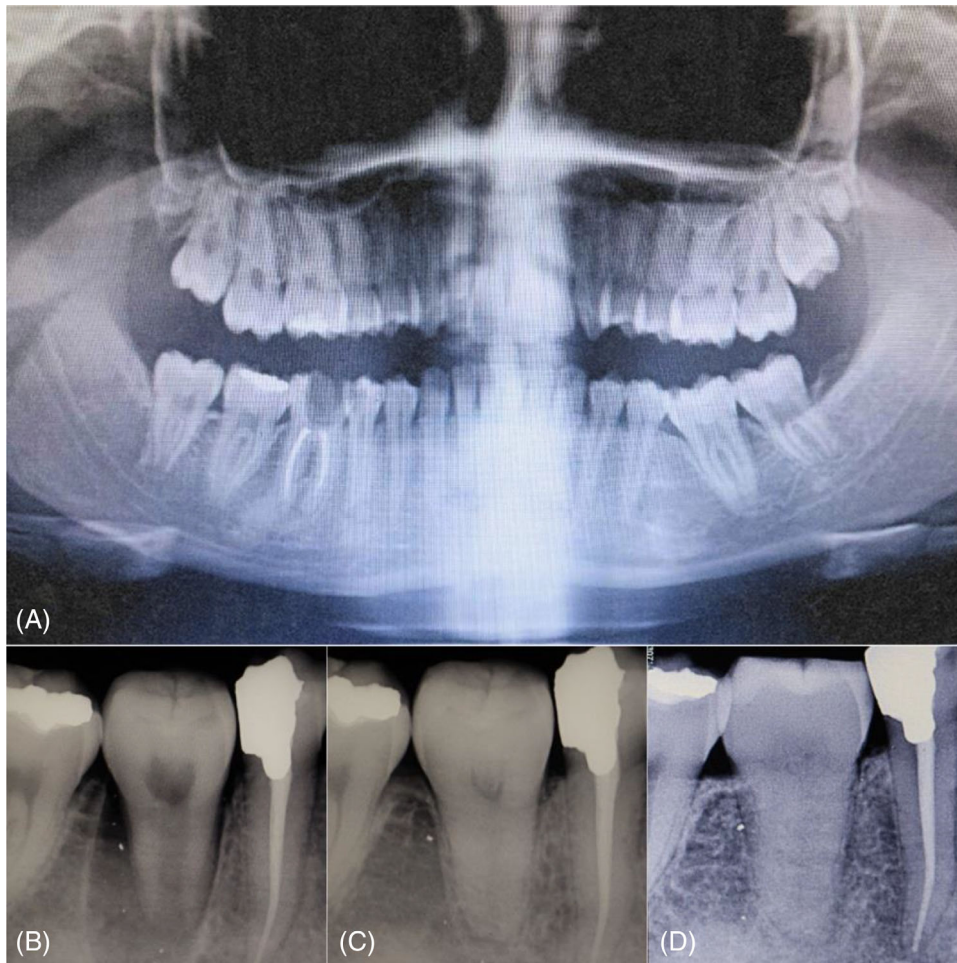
A 17-year-old female patient underwent clinical and radiographic examination, which revealed an extensively decayed tooth (#30) that was beyond restoration. The examination included: (A) A panoramic radiograph demonstrating the overall condition of the teeth, the level of the bone, and the developing third molars. (B) A periapical radiograph immediately after transplantation. (C) A 48-month follow-up radiograph. (D) An 84-month follow-up radiograph.
